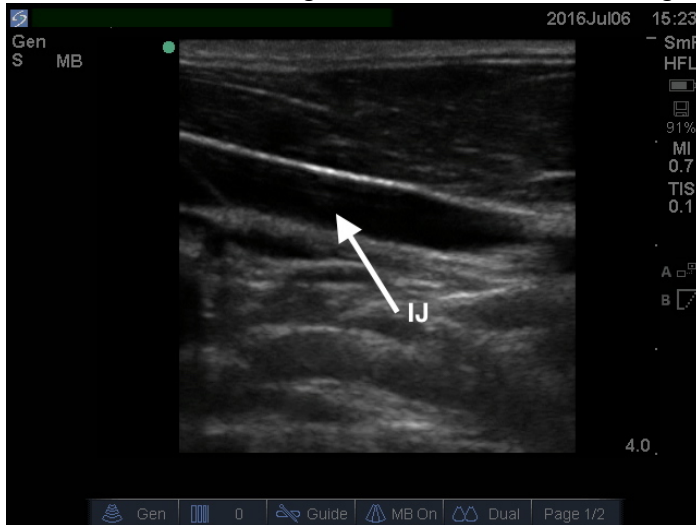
Ultrasound of the internal jugular in the longitudinal plane.
